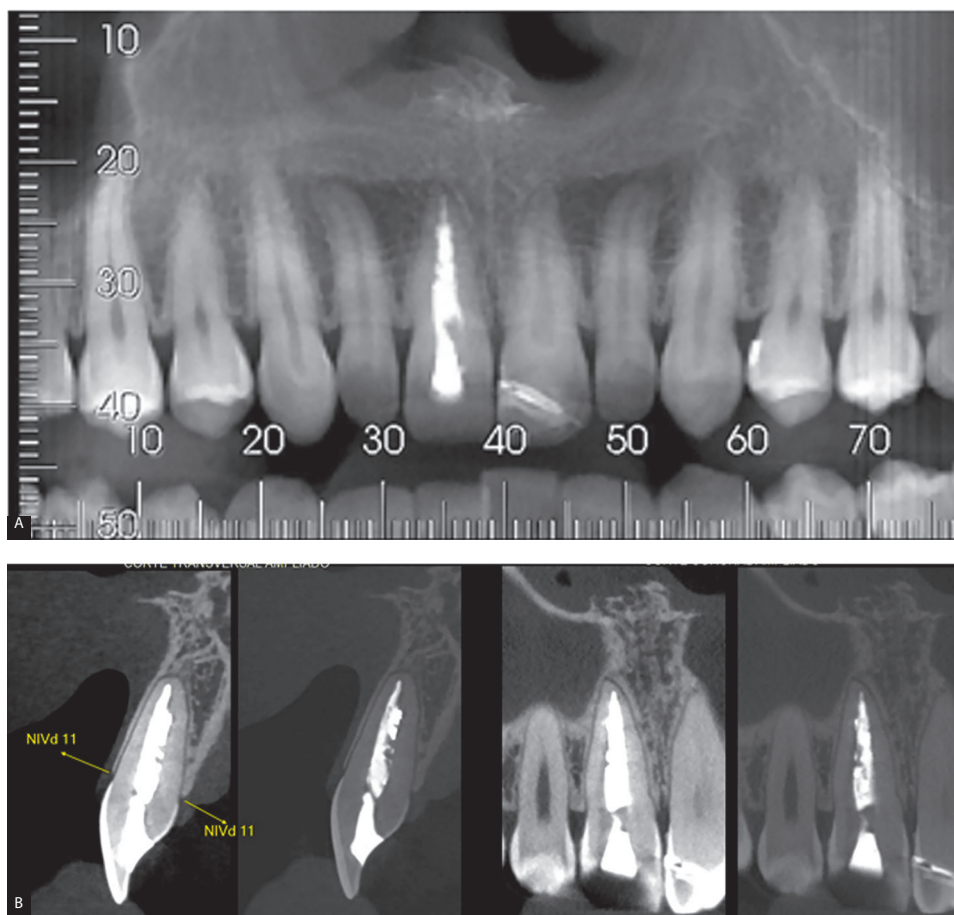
This filter allows CBCT images to be transformed in transparent mode, into images with specific coronary chamber details, as well as clearly visualized volume and adjacent structures.
